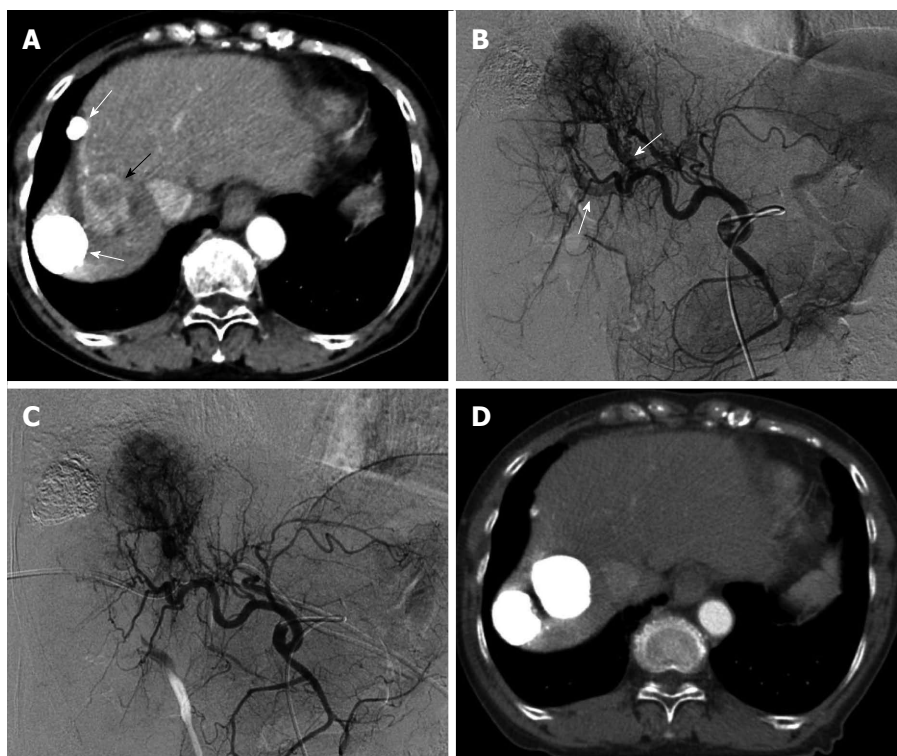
Multiple hepatocellular carcinomas with significant arterioportal shunts in a 71-year-old woman. Enhanced computed tomography (CT) imaging revealed viable hepatocellular carcinomas (HCCs) (A, black arrow) with lipiodol deposit HCCs (A, white arrows). Common hepatic arteriography in the arterial phase (B) demonstrated HCC with significant arterioportal shunts (B, arrows), consisting of P8 and P4. Common hepatic arteriography under balloon occlusion of the portal vein branches of P8 and P4 showed an opacified tumor with non-visualized arterioportal shunts (C). CT images 2 mo after transcatheter arterial chemoembolization under occlusion of the 2 portal vein branches (D) demonstrated a dense lipiodol deposit in the HCC and a complete response, according to modified Response Evaluation Criteria in Solid Tumors.
